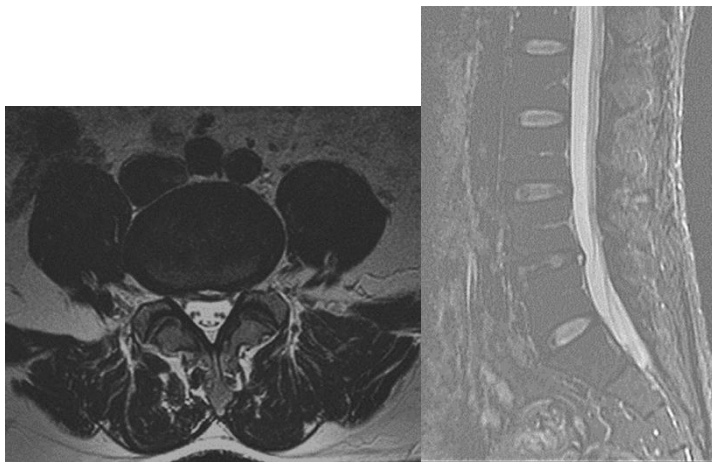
Sagittal and axial images on T2-weighted MRI showed HIZ in L4/5 disc.
